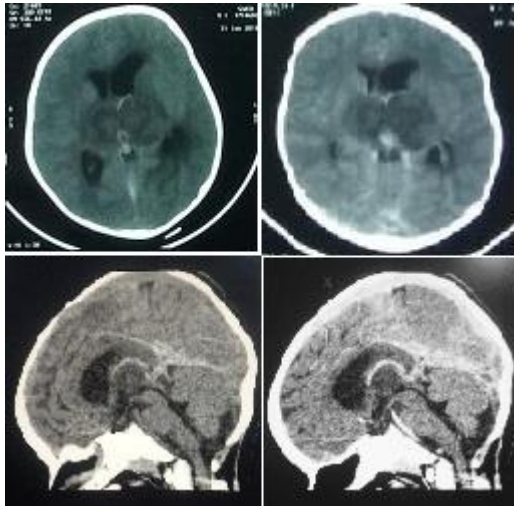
(Top row) Non-contrast (left) and contrast (right) axial computed tomography scan showing bilateral thalamic hypodensity and hyper-dense deep cerebral venous system (on plain scan).
